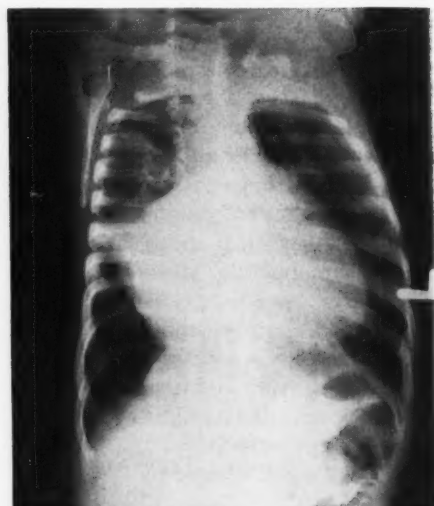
X-ray film of the chest in infant B. J. P. The pulmonary anomaly is evident as well as the pronounced cardiomegaly.
